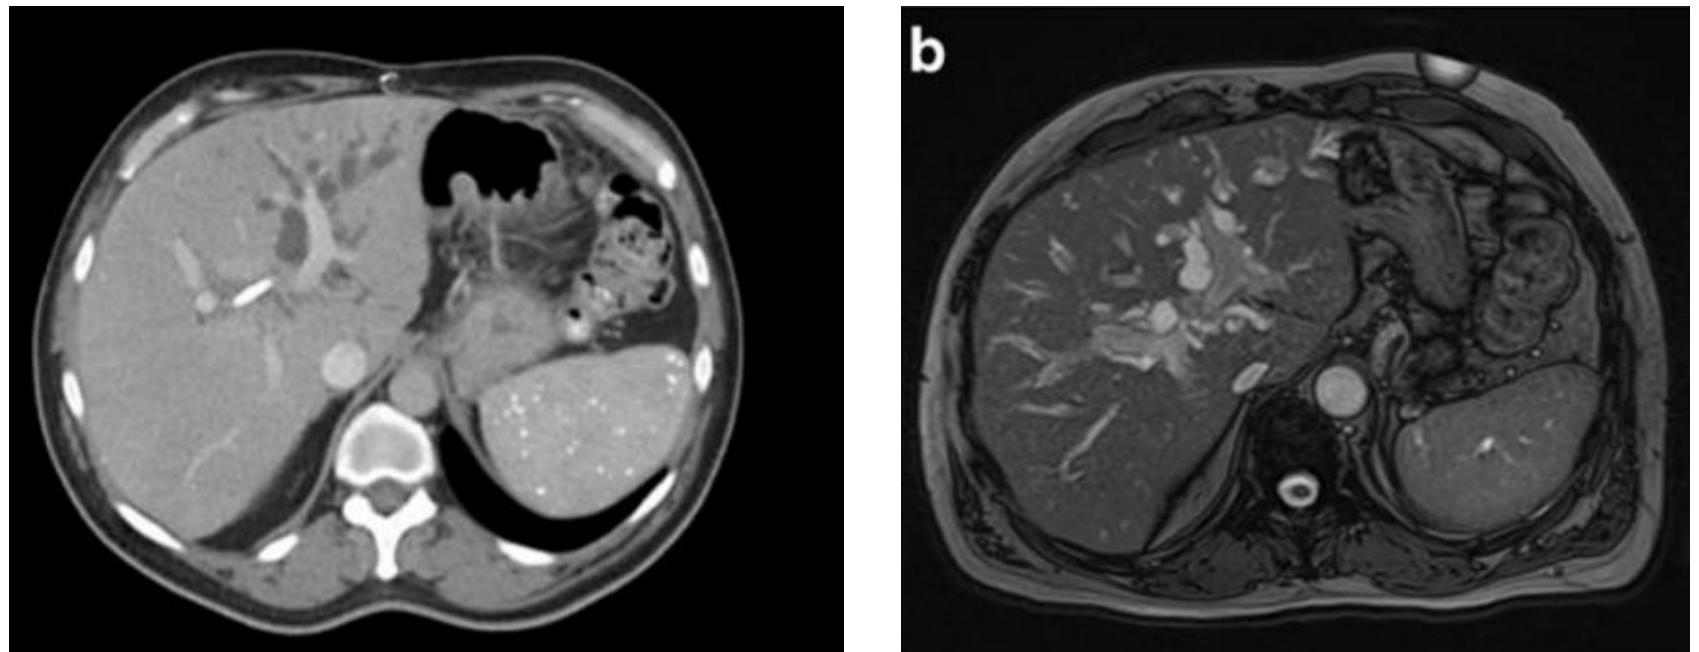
Abdominal CT scan (a) and MRI (b) demonstrating left biliary tree dilatation in a 63-year-old male with hilar cholangiocarcinoma
